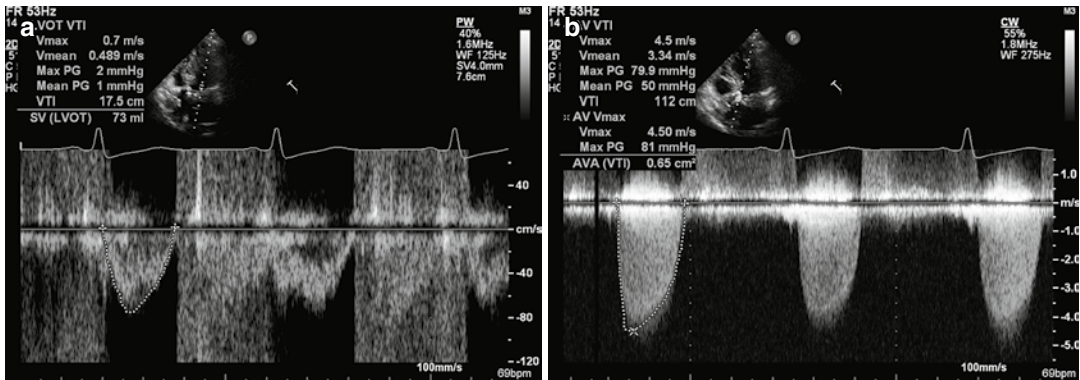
Doppler tracings from the patient. The pulsed wave recording (a) shows normal velocity profile with predominantly laminar flow and a peak velocity of 0.9 m/s. The aortic continuous wave recording (b) shows
